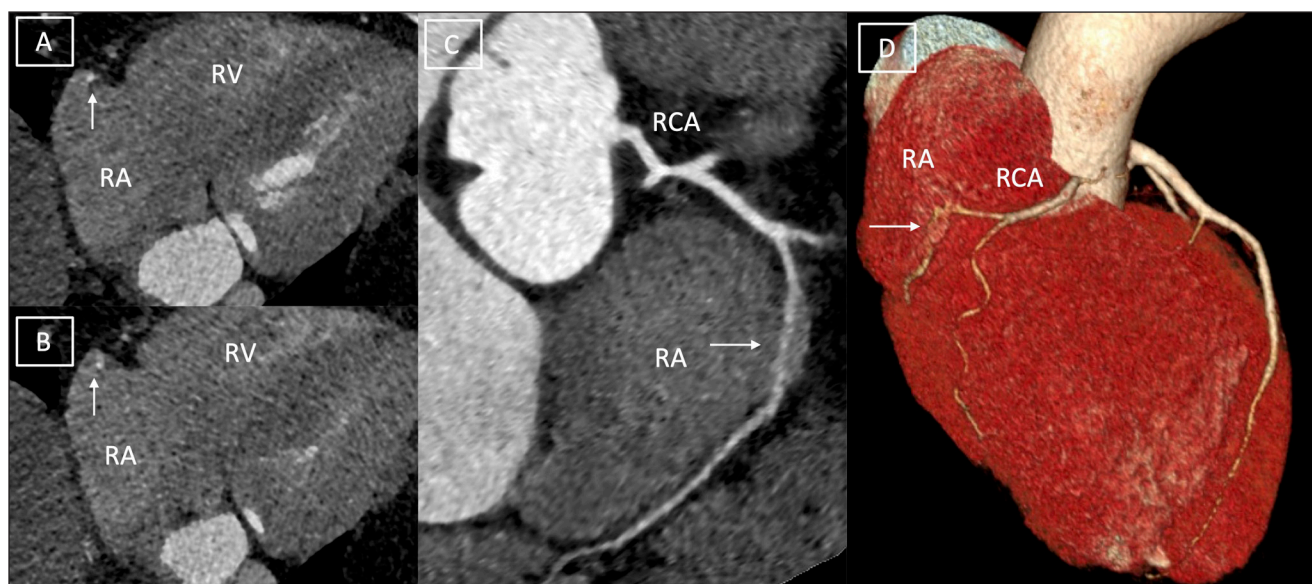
Axial computed tomography image (A, B) depicting intra-atrial course of right coronary artery (RCA, depicted by white arrow). Curvilinear multiplanar image (C) and volume-rendered image (D) demonstrate proximal RCA surrounded by epicardial fat, intra-atrial course of RCA (white arrow) for a length of 3 cm and then normal course of rest of RCA. RV: right ventricle; RA: right atrium
